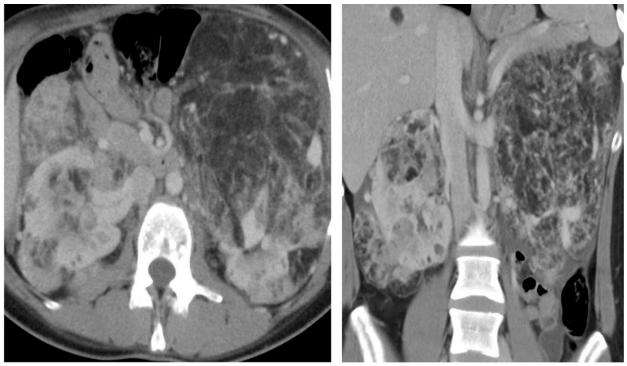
Renal angiomyolipoma (AML). Axial and coronal postcontrast computed tomography images show very large AML in both kidneys in a patient with known tuberous sclerosis complex. The left renal AML is very large and at risk for bleeding. Note a small AML in the liver.
